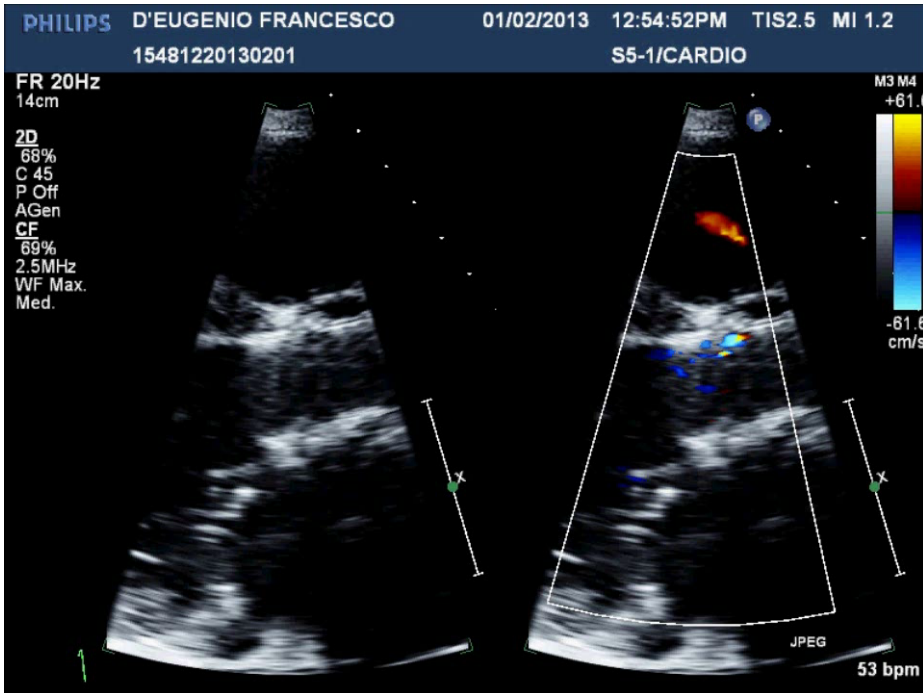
Transesophageal Color Doppler Echocardiographic Views for the Assessment of PVR
